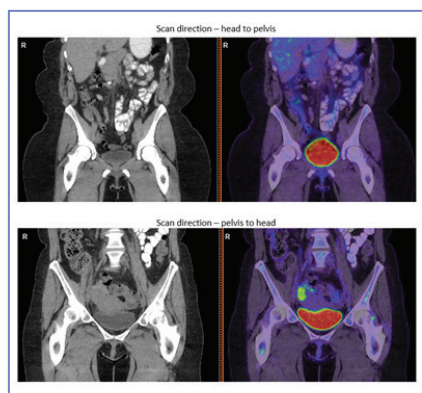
Two [¹⁸F]FDG PET scans performed on women with ovarian cancer.
